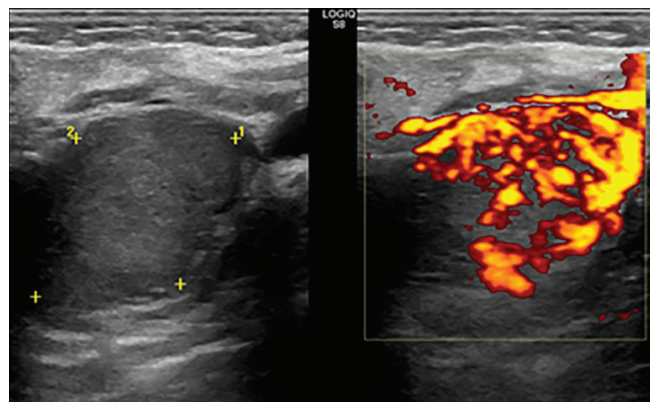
Frontal sections: Compound 38 × 26 mm tumor in the submandibular area with low echogenicity, homogeneous texture and high vascularity in Power Doppler
